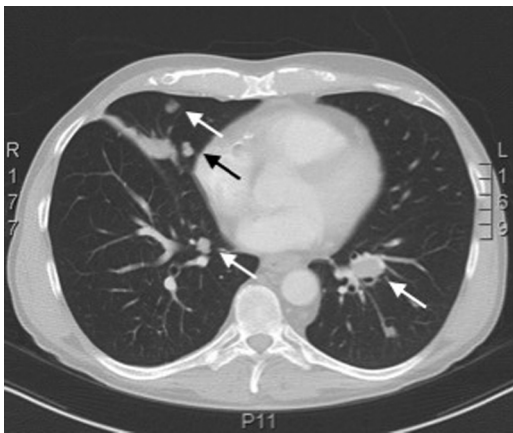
CT of the chest showing multiple bilateral lung nodules (white and black arrows).
